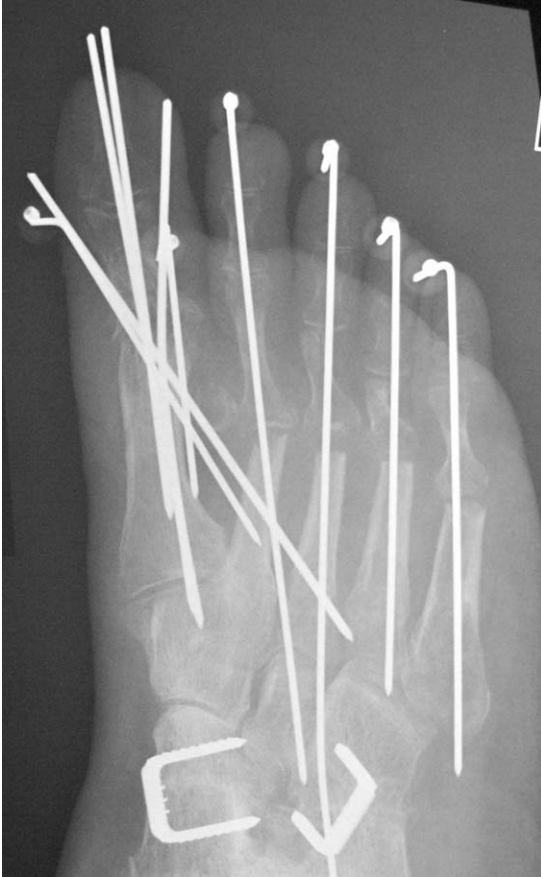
A/P radiograph of a first metatarsophalangeal arthrodesis using retrograde threaded Steinmann pins. Metatarsal head resections have been performed of the lesser toes stabilized with longitudinal smooth Kirshner wires.
